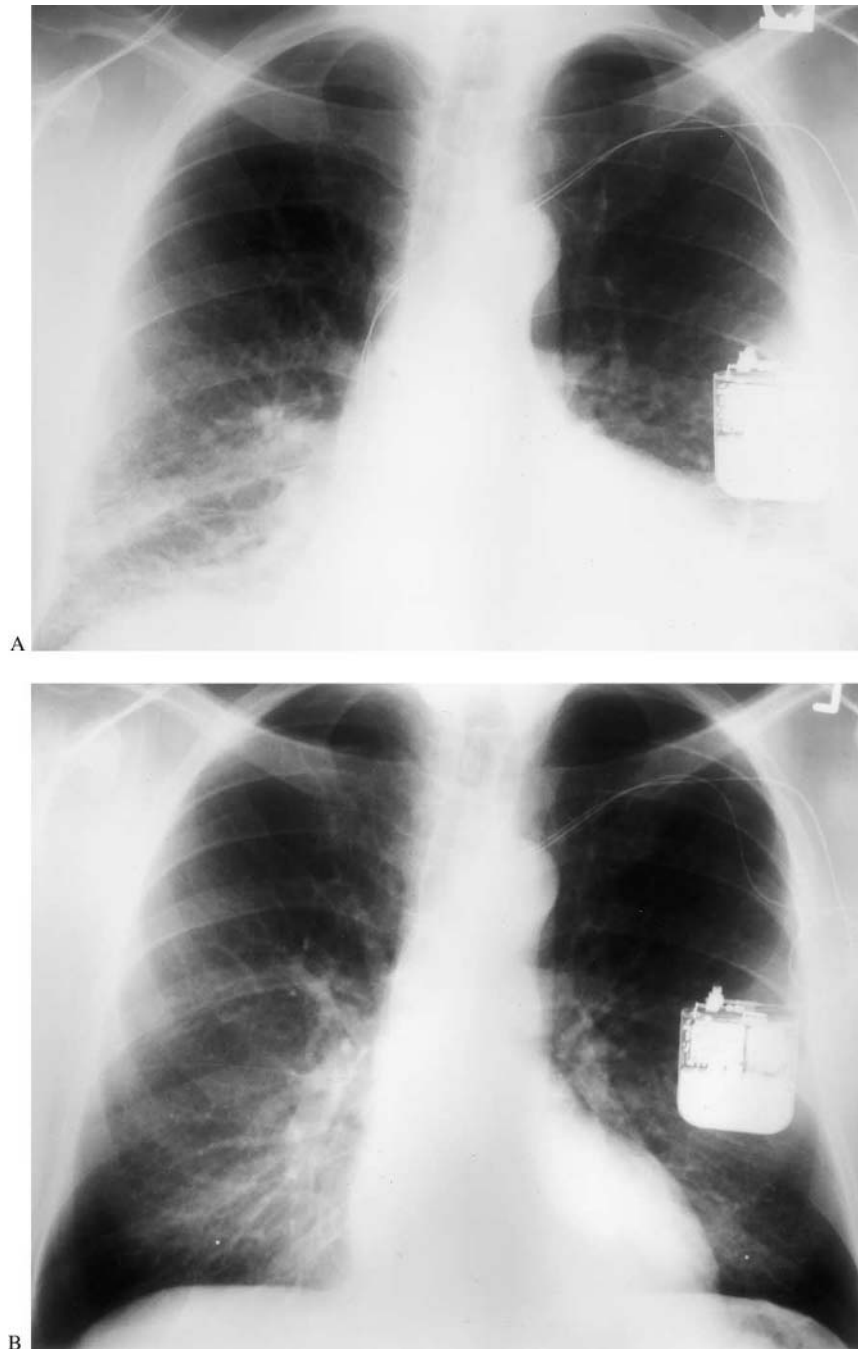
(a) Polymyositis. PA chest radiograph from a 70-year-old male with polymyositis and a restrictive ventilatory defect reveals bilateral reticular opacities, with a basilar predominance. A left cardiac pacemaker is in place. Transbronchial lung biopsies revealed chronic interstitial inflammation and fibrosis. (b) Polymyositis. PA chest radiograph from the same patient 3 months later following high dose corticosteroid therapy has completely normalized. (Reproduced with permission from Lynch and Chavis, 1992.)
